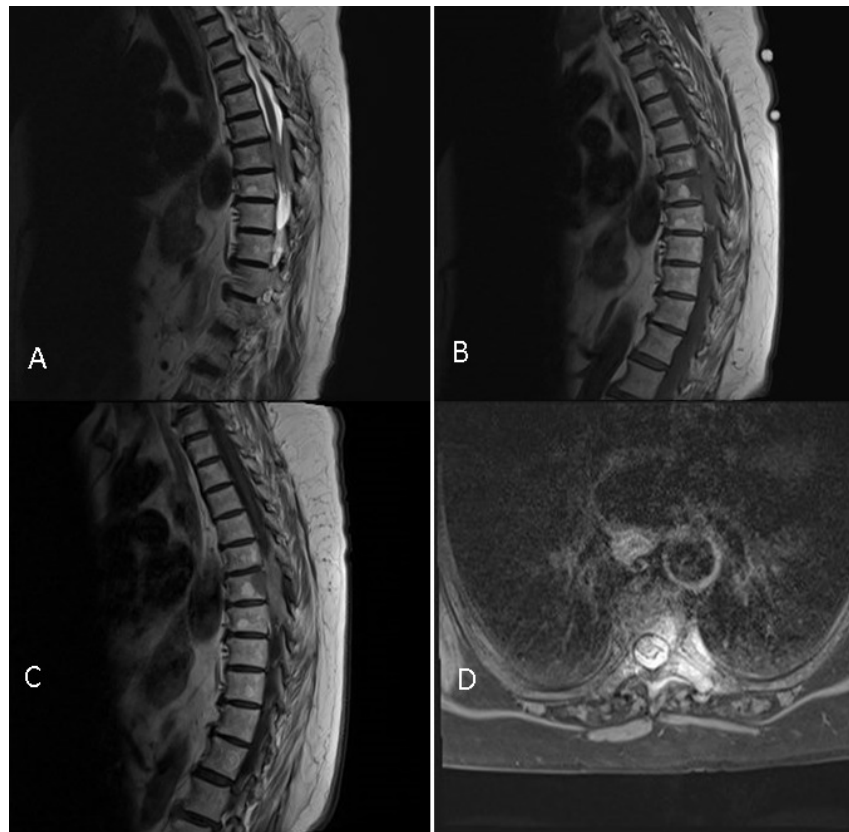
(A) Preoperative sagittal T1W, (B) sagittal T2W, (C) post-contrast sagittal and (D) post-contrast axial MR images of the patient showing a soft tissue component with T1W and T2W hypointense signal characteristics, and extending from the left posterior elements and Th6-7 and Th7-8 foramens, posterior to the Th7 vertebral corpus.
